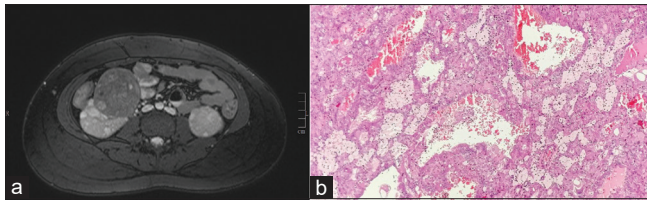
(a) Contrast-enhanced MRI axial image of kidneys. There is a T1 hypointense and T2 hyperintense exophytic heterogeneously enhancing mass arising from the medial cortex of the lower pole of the right kidney. Cystic lesions are seen as hypointense lesions in the remaining visualized parenchyma. Axial short tau inversion recovery image shows a heterogeneous mass with multiple internal hyperintense areas suggestive of necrosis. (b) Papillary pattern composed of cells with abundant eosinophilic cytoplasm and hyperchromatic irregular nuclei with punctate nucleoli. Hob-nailing of cells is also seen focally.
